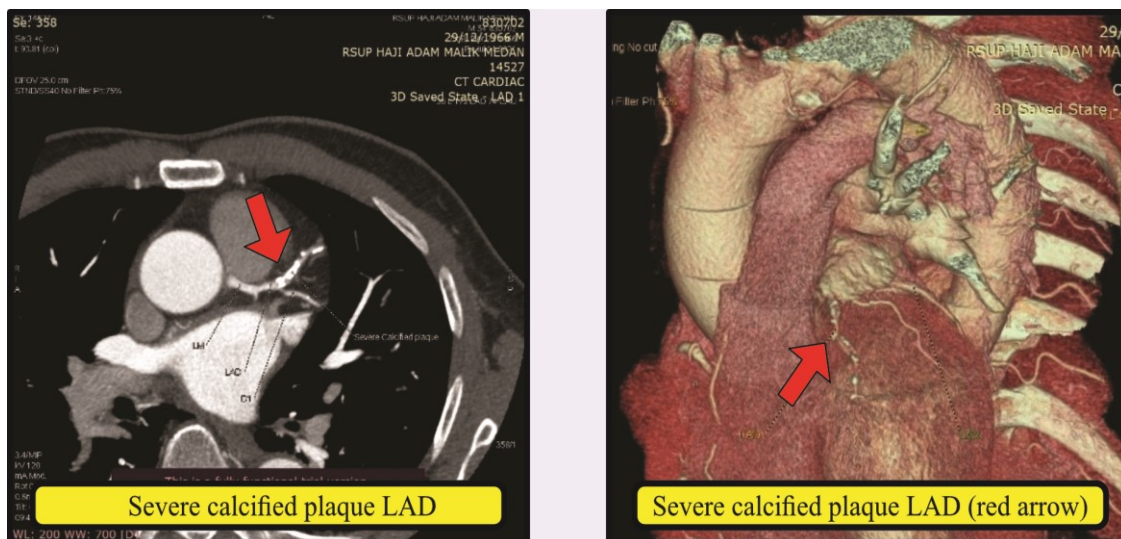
Computed tomography results with Multiple Occlusion, Severe Calcification and bending $\geq 45^\circ$ (red arrow)
